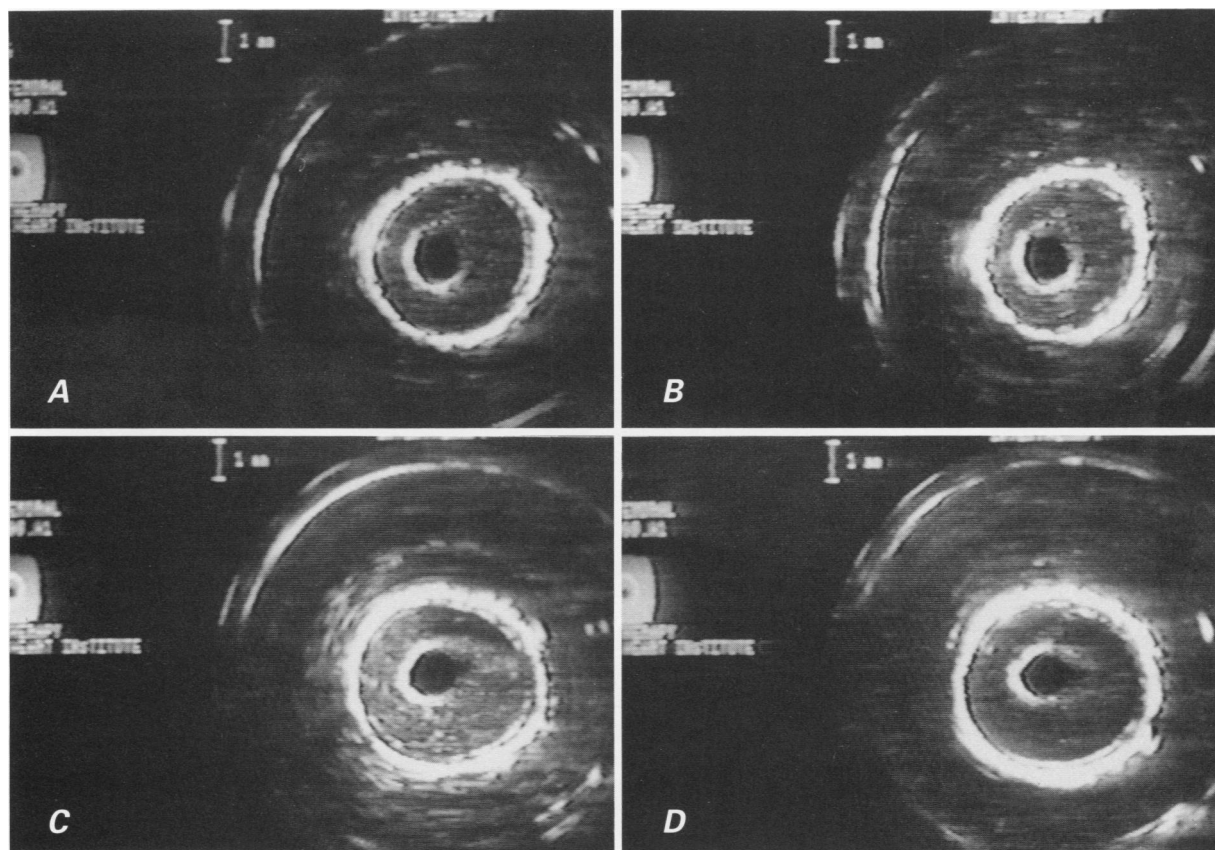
The progression of thrombus over time, as visualized by intravascular ultrasound. In sequence are shown: A) low flow, with a small deposition of thrombus; B) zero flow (at 2 minutes), with a larger volume of obstructing thrombus; C) zero flow (at 4 minutes), with a more uniform appearance of the thrombus; and D) full flow (after striking the artery to dislodge the thrombus), with no obstructing thrombus visible.
